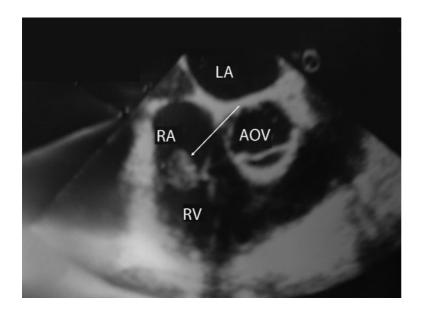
Echocardiogram showing a large vegetation (arrow) of the tricuspid valve. AOV, Aortic valve; LA, left atrium; RA, right atrium; RV, right ventricle.
